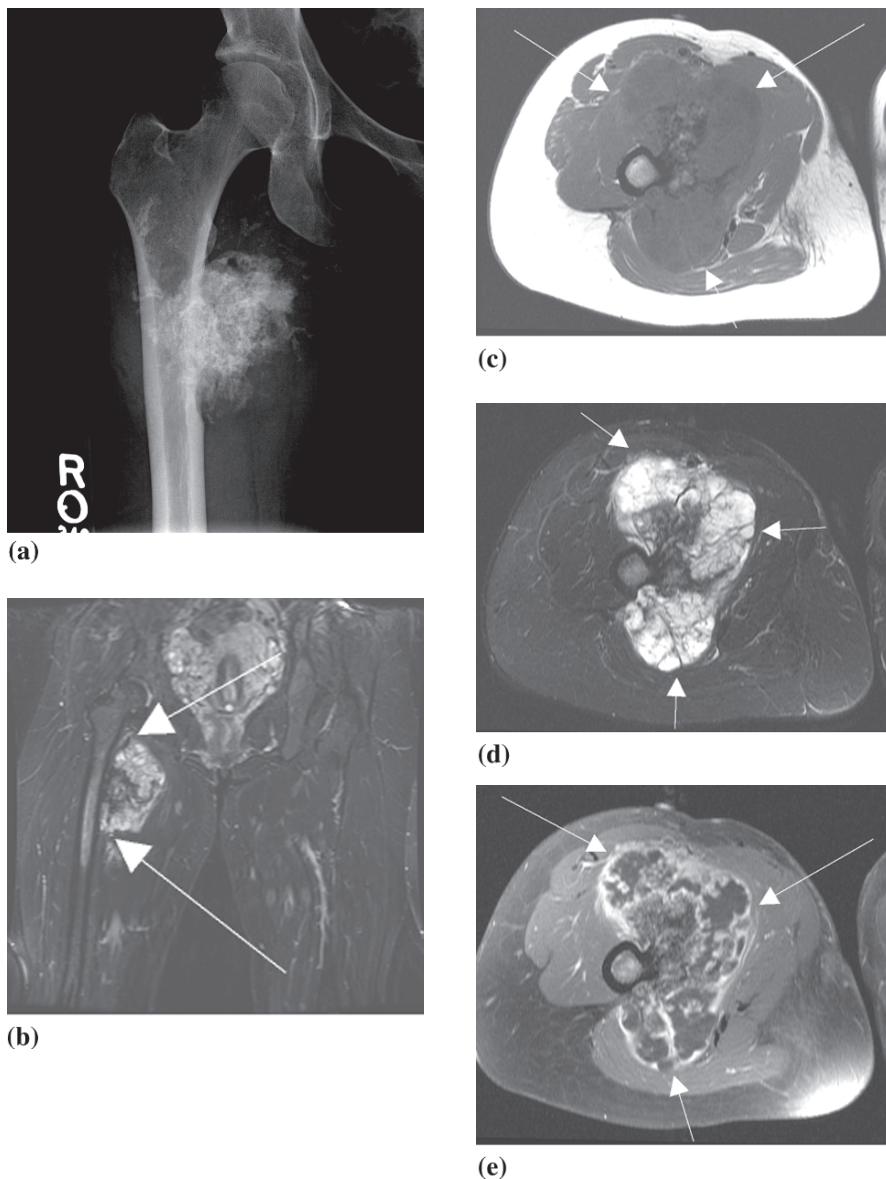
Low-grade juxtacortical chondrosarcoma in 34-year-old female. (a) Frontal radiograph displays a dense “arcs-and-rings” mineralization pattern associated with a partially calcified soft tissue mass. (b) Coronal STIR, (c) axial proton density, (d) axial STIR, and (e) axial T1 post-gadolinium fat saturation images show the T2 hyperintense cartilage within the lesion (best seen on the STIR image) and nodular peripheral and septal enhancement (best seen on the T1 post-contrast image). Note the excellent soft tissue contrast which permits evaluation of neurovascular structures for resection planning
